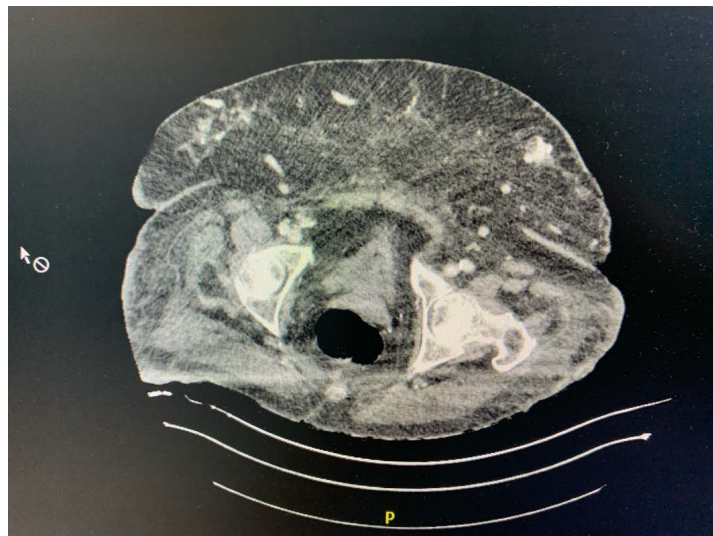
Abdominal computed tomography: deep collection in subcutaneous fat corresponding to the area of necrosis.
